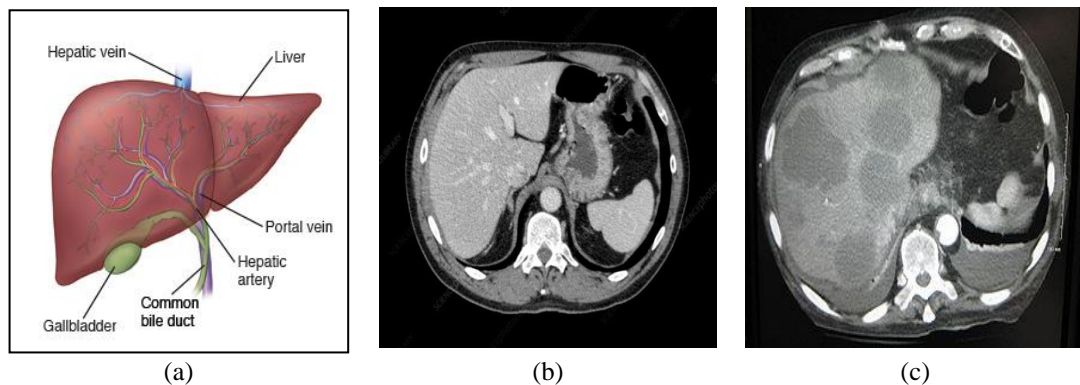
The liver anatomy: (a) liver structure, (b) normal liver CT image, and (c) liver cancer CT image
